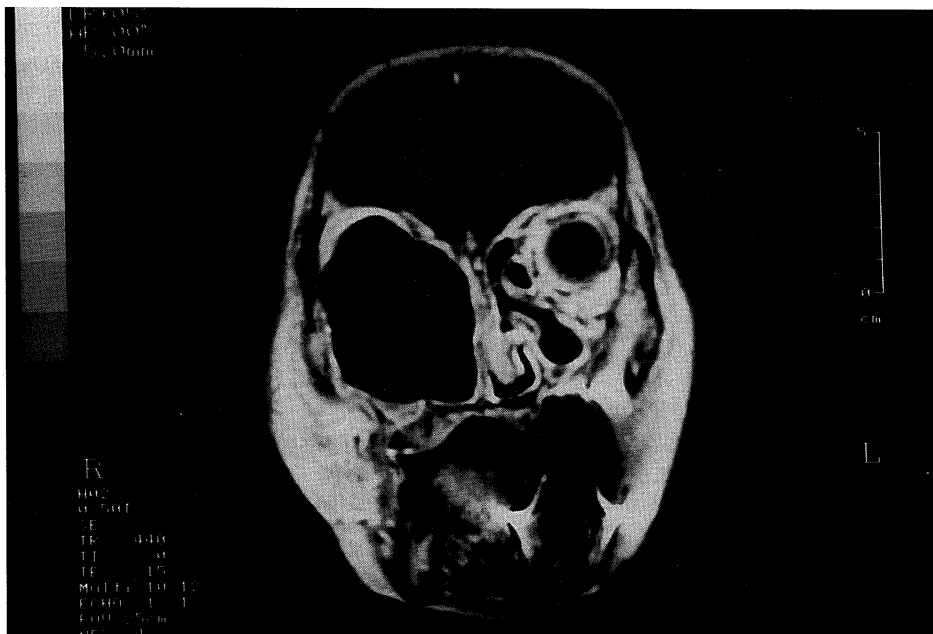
MRI after treatment showed no recurrence of tumor
